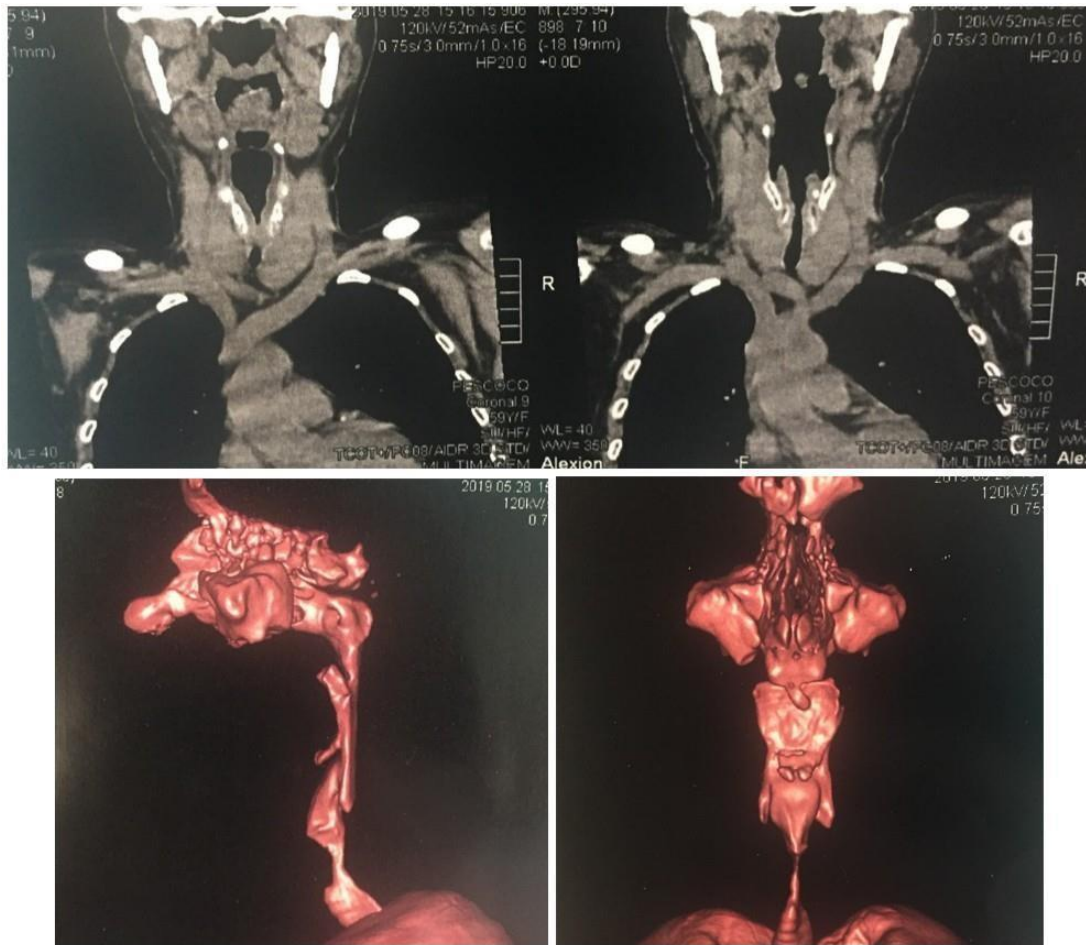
Computed tomography (CT) of the neck shows small calcification areas in the infraglottic region (proximal cervical trachea). Minimal transverse area of air column measuring 32mm².
